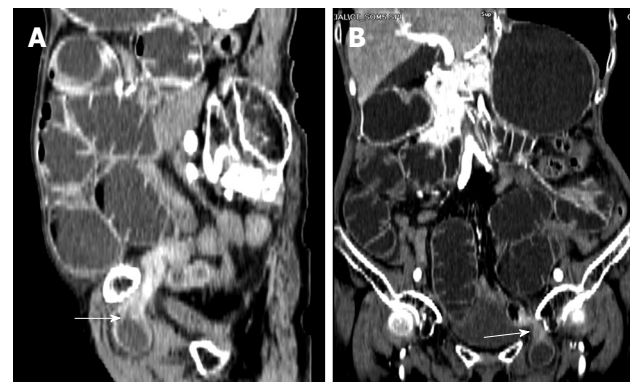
Three-dimensional reconstructed CT (A: Sagittal section; B: Coronal section) finding extensive dilation of the small bowel loops and a loop of small bowel protruding into the left obturator canal with the transition zone from dilated to collapsed bowel (arrows).
